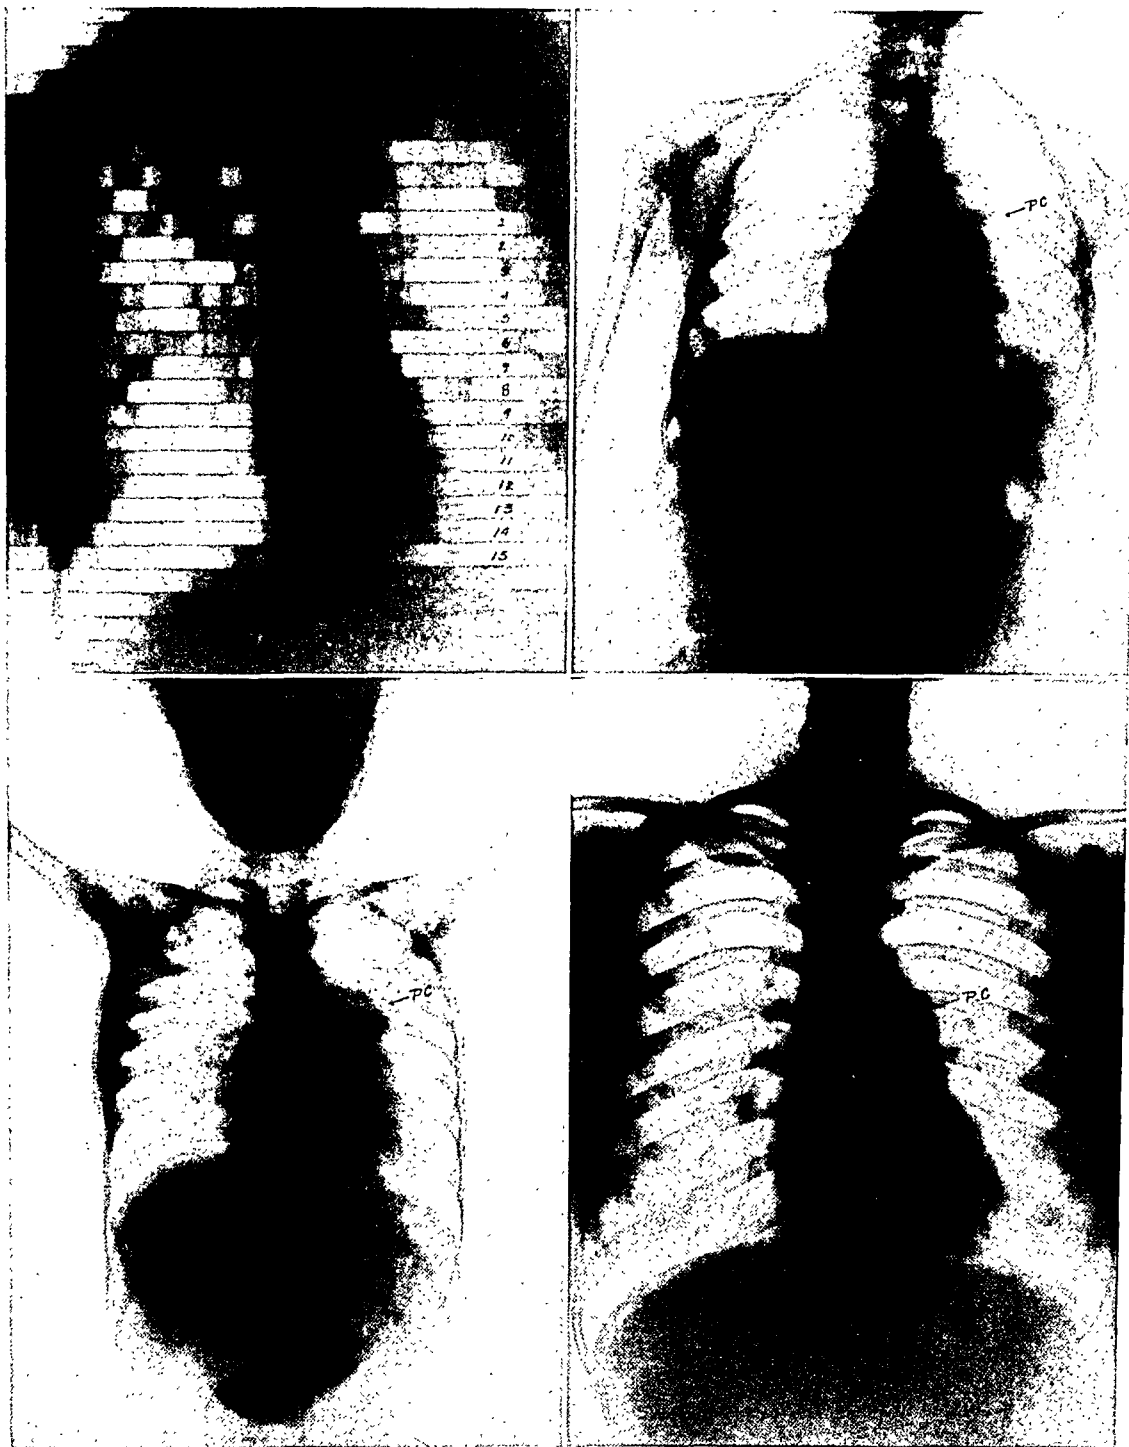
B (*upper left*). Anterior roentgen kymogram. Left frames: 1-2 aortic waves, 4-5 pulmonary conus, 7 auricular, 9-15 left ventricular. Right frames: 1-8 vena cava superior, 9-11 right auricular, 12-15 right ventricular.
